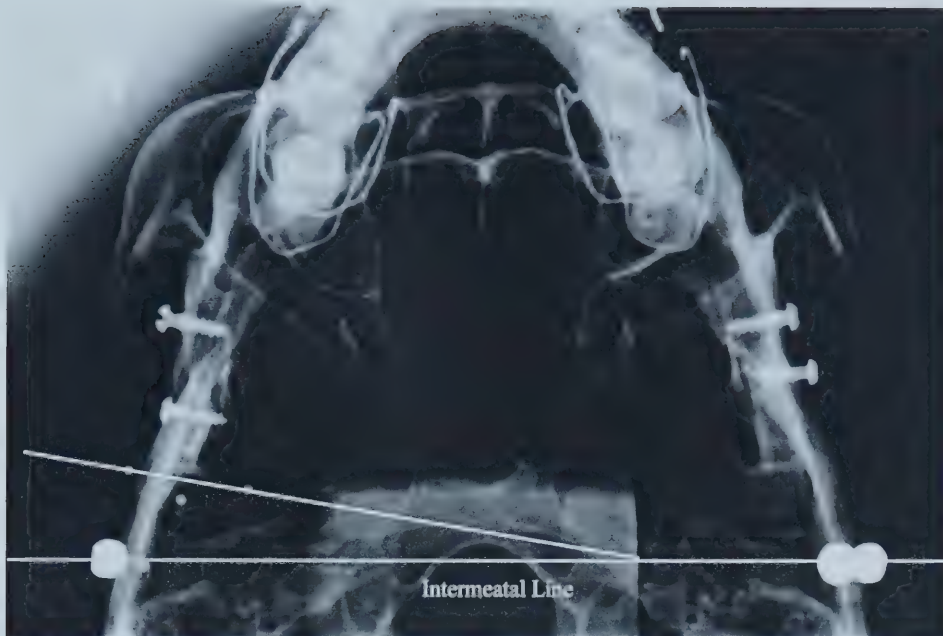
Submentovertex Projection for Horizontal Condylar Axis Angulation. The angle formed by the mediolateral long axis of the condyle and the intermeatal axis is used to calculate the horizontal condylar axis angulation in axially corrected tomography. Note that the intermeatal line is constructed by connecting the radiographic images of the cephalostat ear rods.
